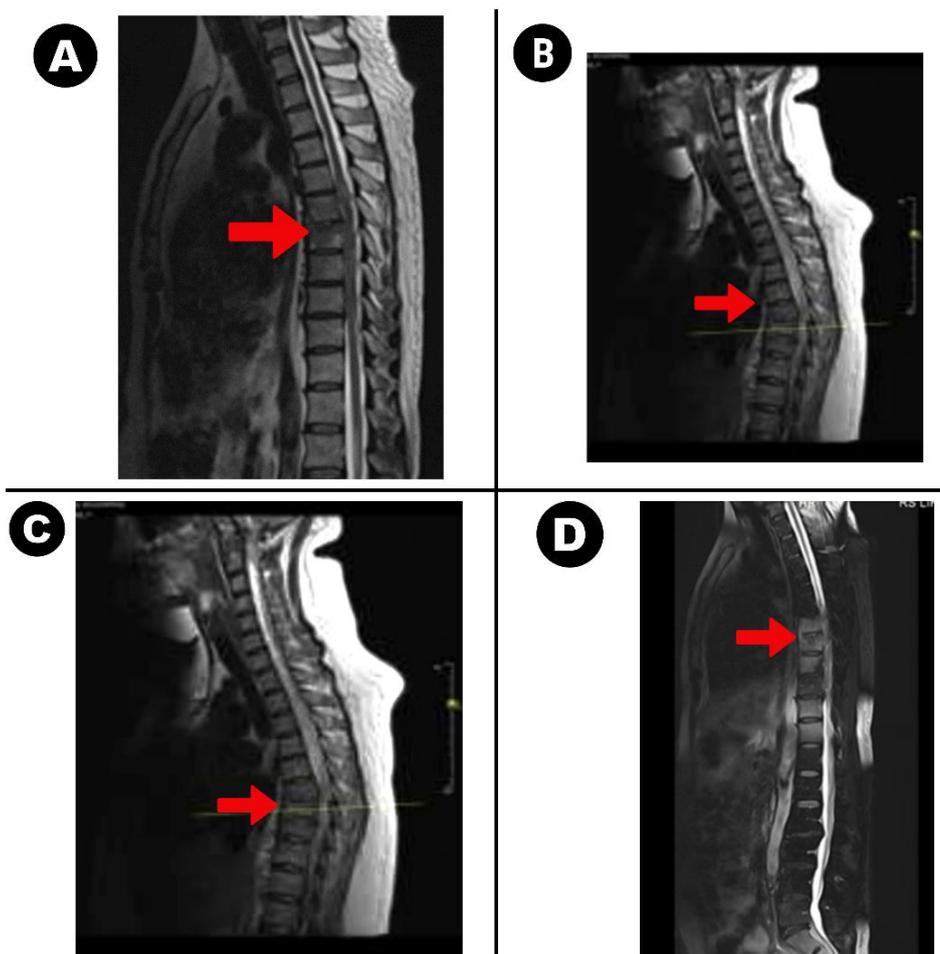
MRI of Spinal TB based on different locations of column involvements with red arrows pointing at the following lesions: a) Paradiscal, b) Central, c) Anterior, d) Posterior.
